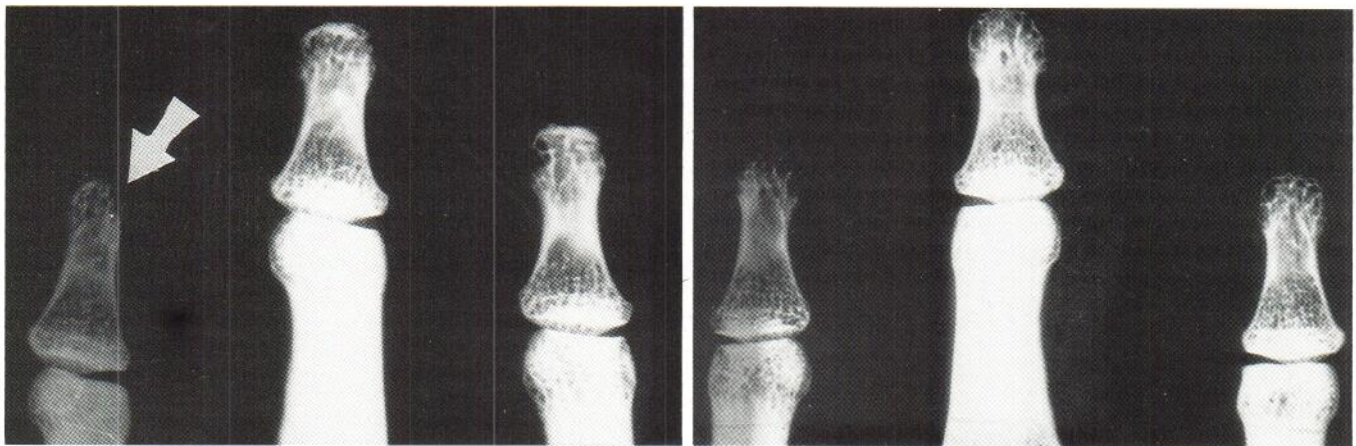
(Left A - Right B) Comparative X-rays of the hands showing initial resorption of the distal phalanges of the 2nd, 3rd and 4th left finger. Note penicilling of the 2nd finger.
